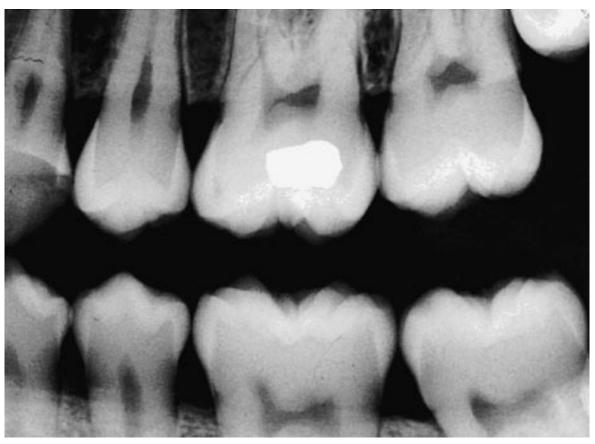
Antemortem bitewing radiograph.
